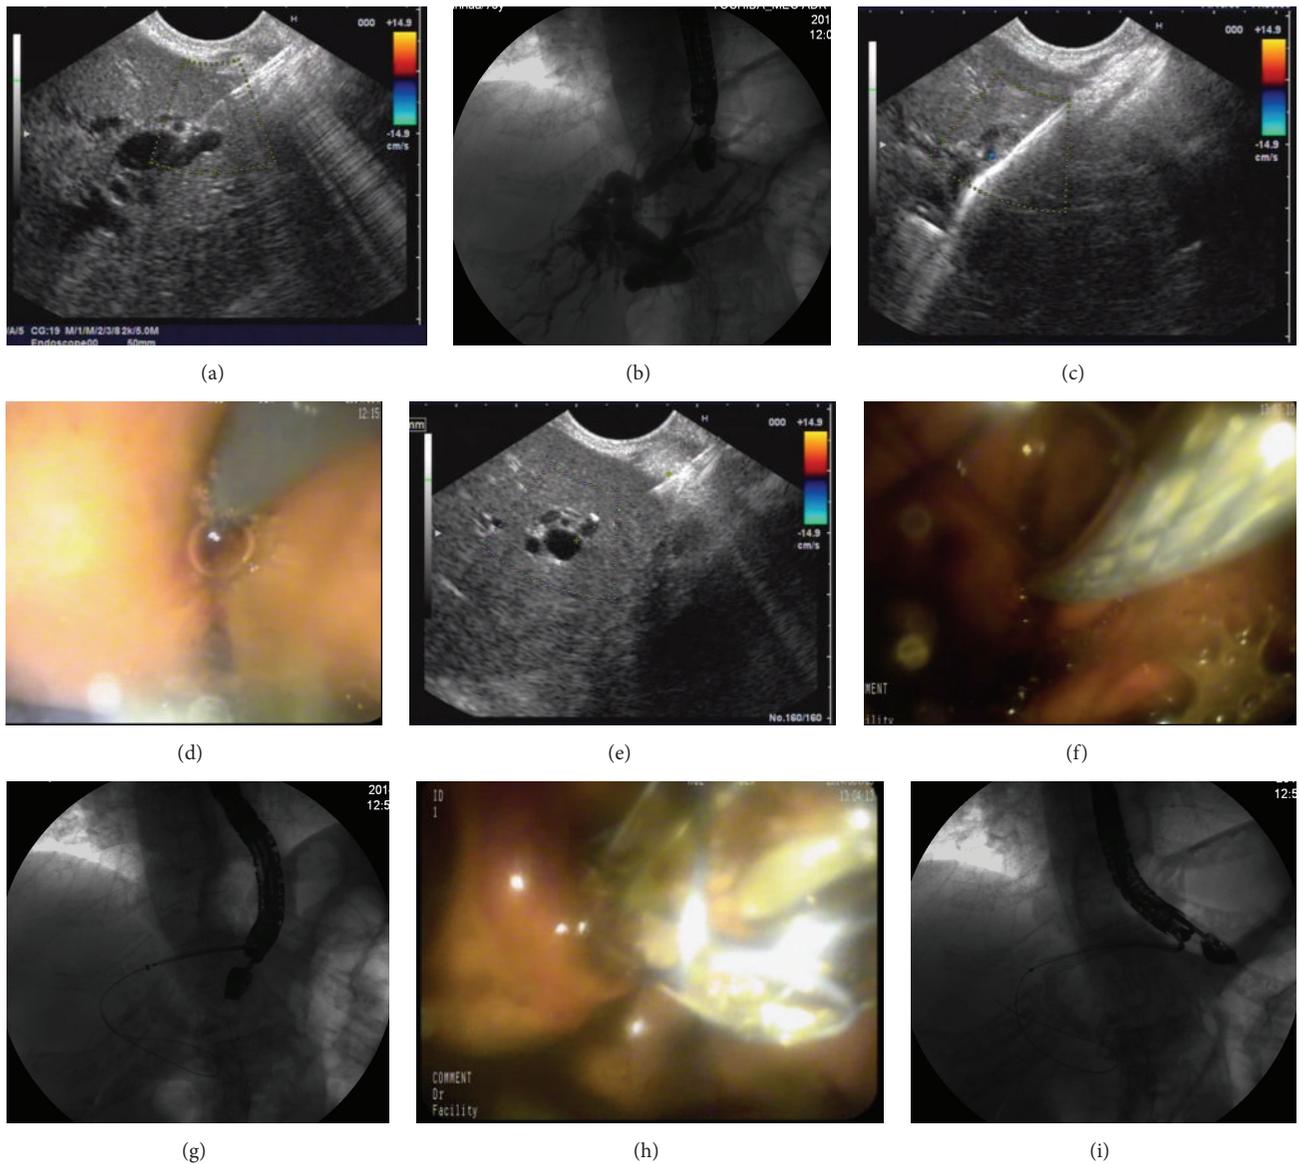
(a) Echoendoscope was advanced into the stomach. After checking local vasculature with color Doppler, the EUS puncture needle was then advanced into the intrahepatic duct. (b) Cholangiography was performed, which usually delineates the dilated biliary tree down to the point of obstruction. (c) A guidewire was then inserted through the needle. (d) The cystotome was used to create a fistula between the stomach and the left hepatic duct. (e) The distance between the stomach and the left hepatic duct was measured. (f)–(i) Once the fistula has been dilated, a fully covered SEMS (10 mm diameter × 8 cm length, fully covered with a silicon membrane) was inserted and deployed transmurally.
